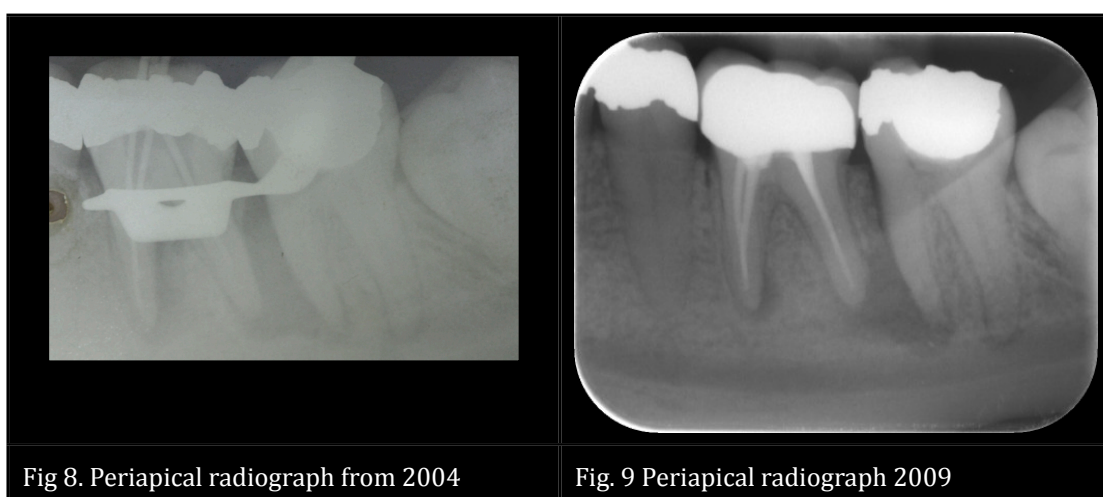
Periapical radiograph from 2004
